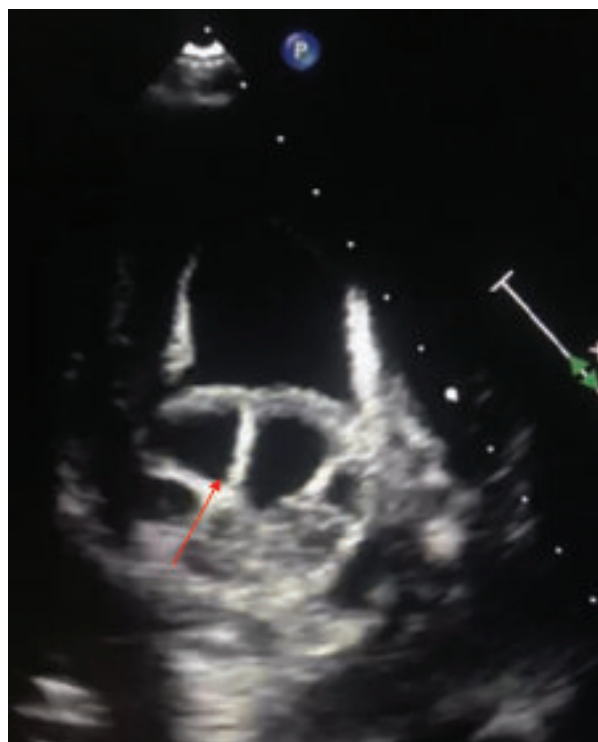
Apical 2 Chamber view showing a large multi-loculated cyst in left ventricle.
